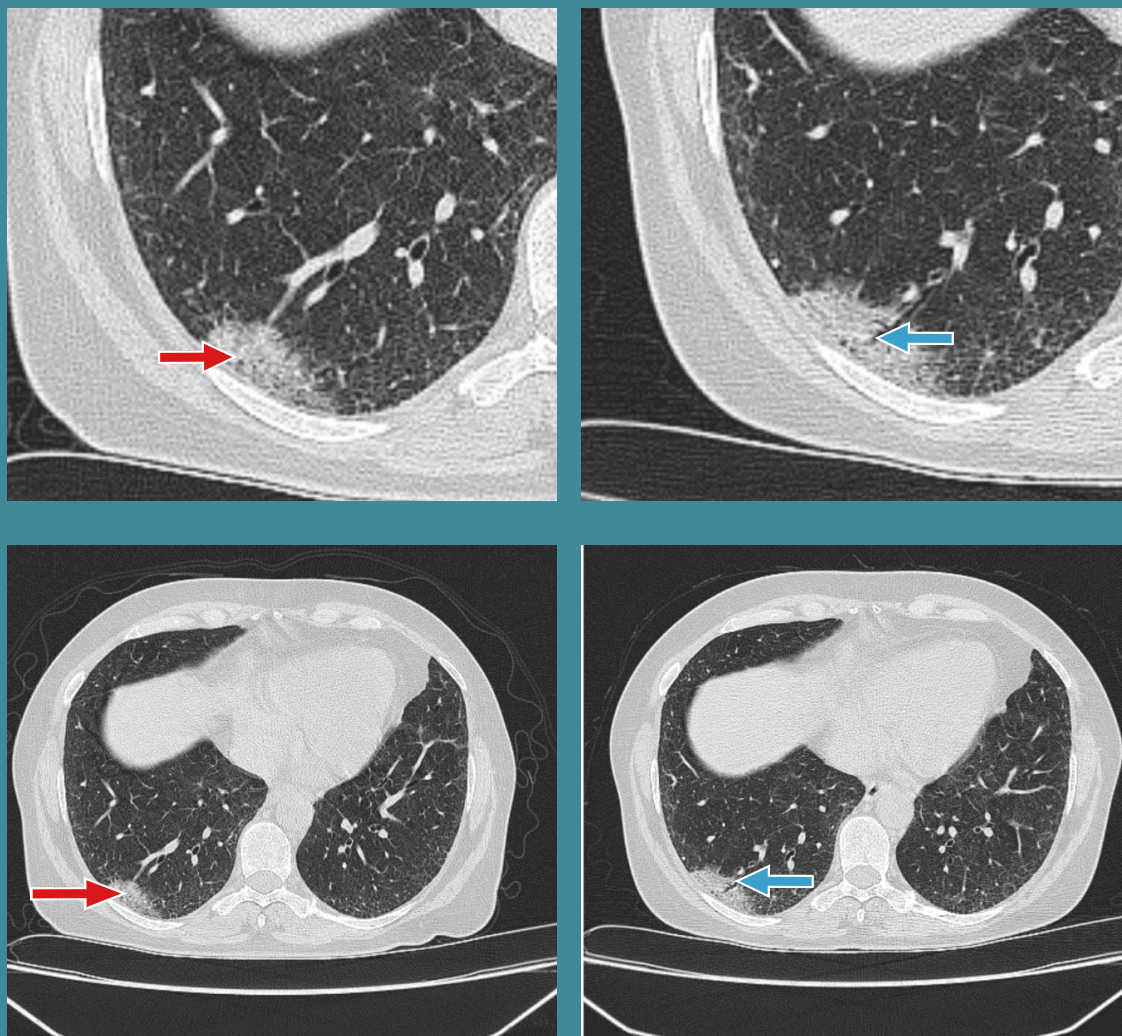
The right CT scan (June 2020) shows a process of subpleural pulmonary condensation at the RLL level, with suspicious CT features (red arrow), dimensionally stable compared to the left CT scan (march 2020), but with progression through aeric bronchogram (blue arrow)
